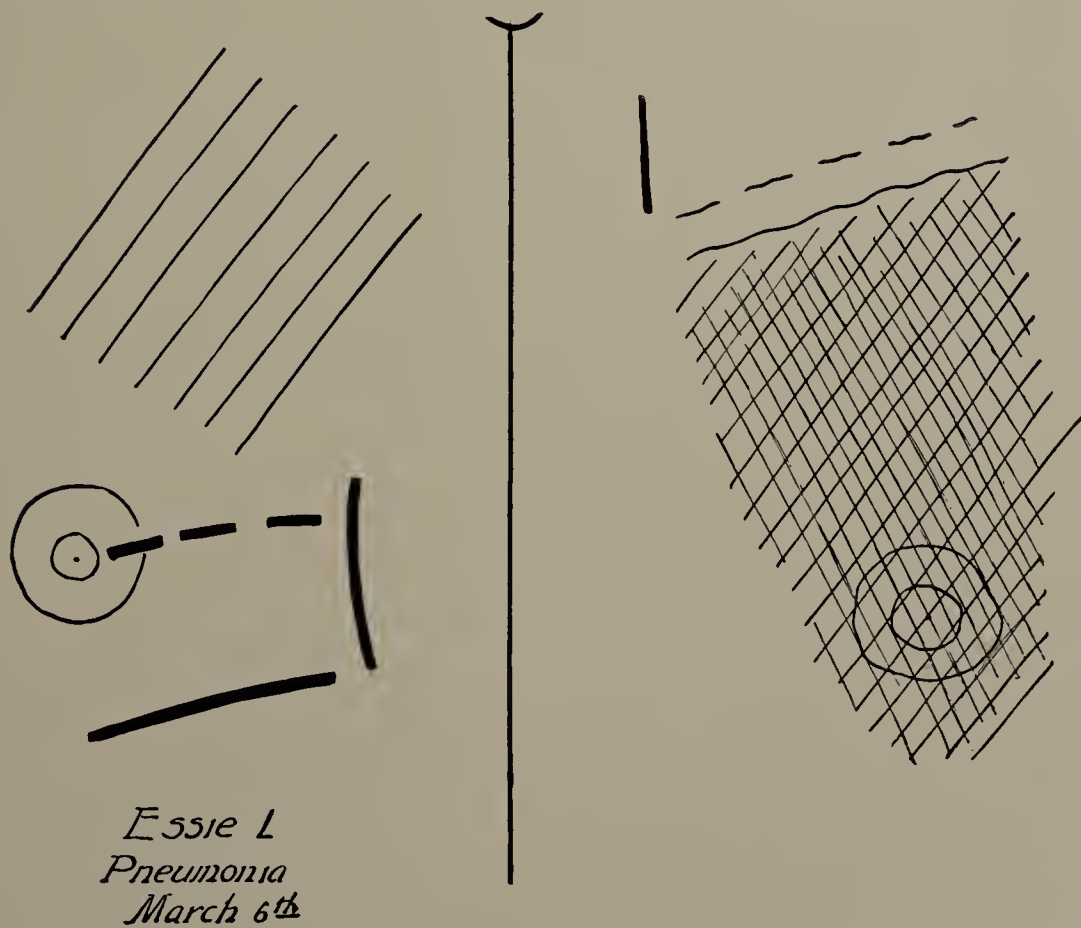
Essie L. March 6. Second X-ray tracing. Broken line shows position of darkened area in expiration; full line in inspiration. Right heart in normal position. (One-third life size.)
